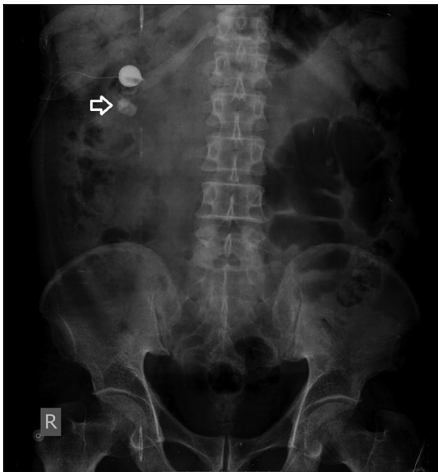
Postpercutaneous nephrolithotomy of the kidneys, ureters, and bladder X-ray showing residual calculi (arrow). There is a contrast in the Foley catheter balloon used as nephrostomy
